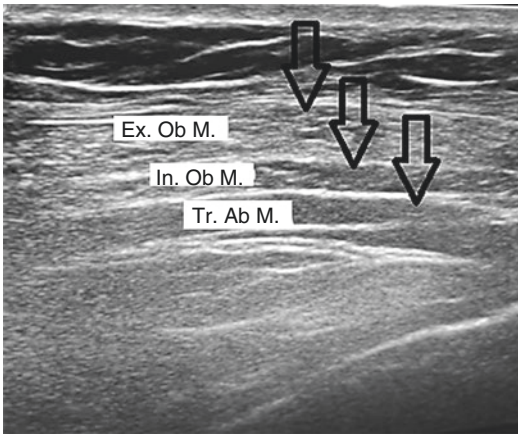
Ultrasound guidance to locate sites for BTA injection. External Oblique Muscle (Ex Ob M.); Internal Oblique Muscle (In. Ob M.); Transversus Abdominus (Tr. Ab M)
